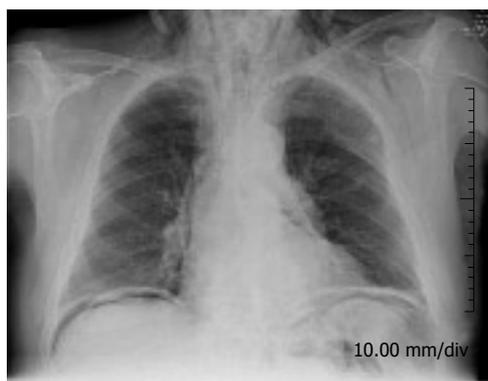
Thorax X-ray examination of the patient showing free air in abdomen, pneumomediastinum and severe subcutaneous cervical emphysema.
